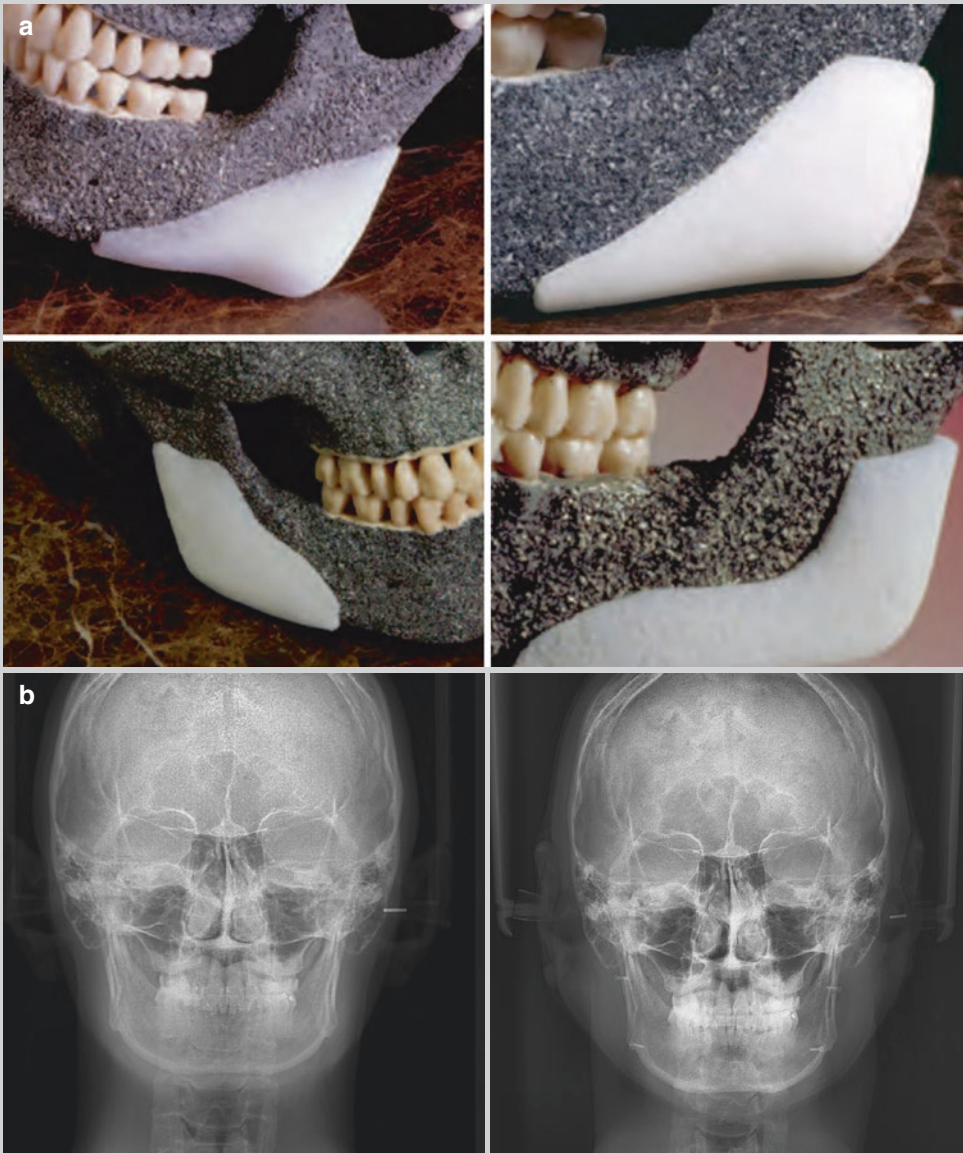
Various ready-made Medpor® implants suited for the mandibular angle. (Lower left) preop x-ray, after insertion of medpor implant and fixation with screws
